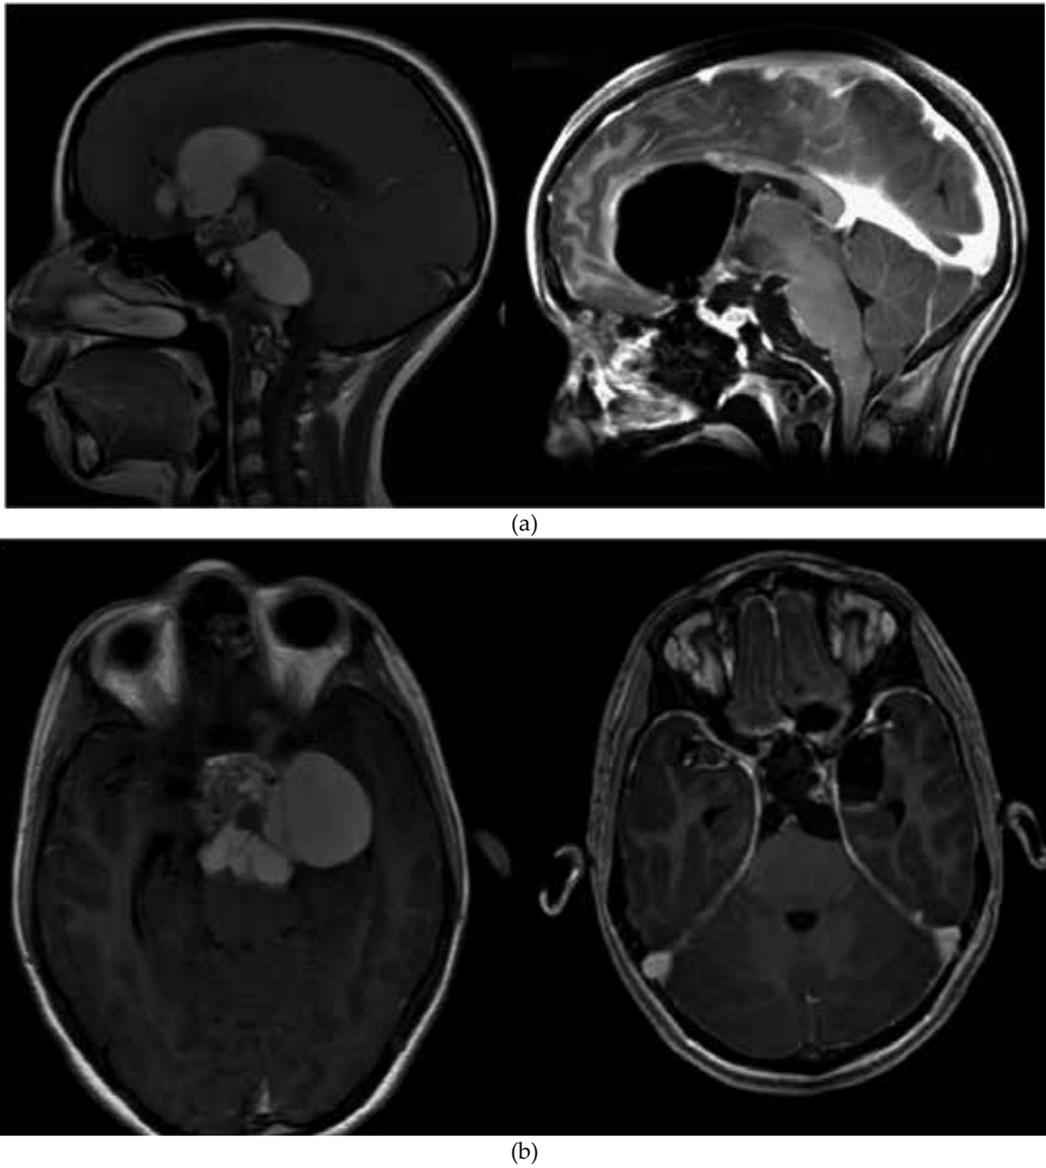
Post contrast T1-weighted preoperative and intraoperative Sagittal (a.) and axial (b.) images in 12 year old female with giant polycystic Craniopharyngioma with 2 cm enhancing nodule. iMRI was helpful in determining complete removal of enhancing nodule and drainage of all major cyst compartments following endoscopic midline approach from posterior ethmoids to clivus, working above and below pituitary gland, air visualized on intraoperative images was irrigated out of ventricles prior to closure.
